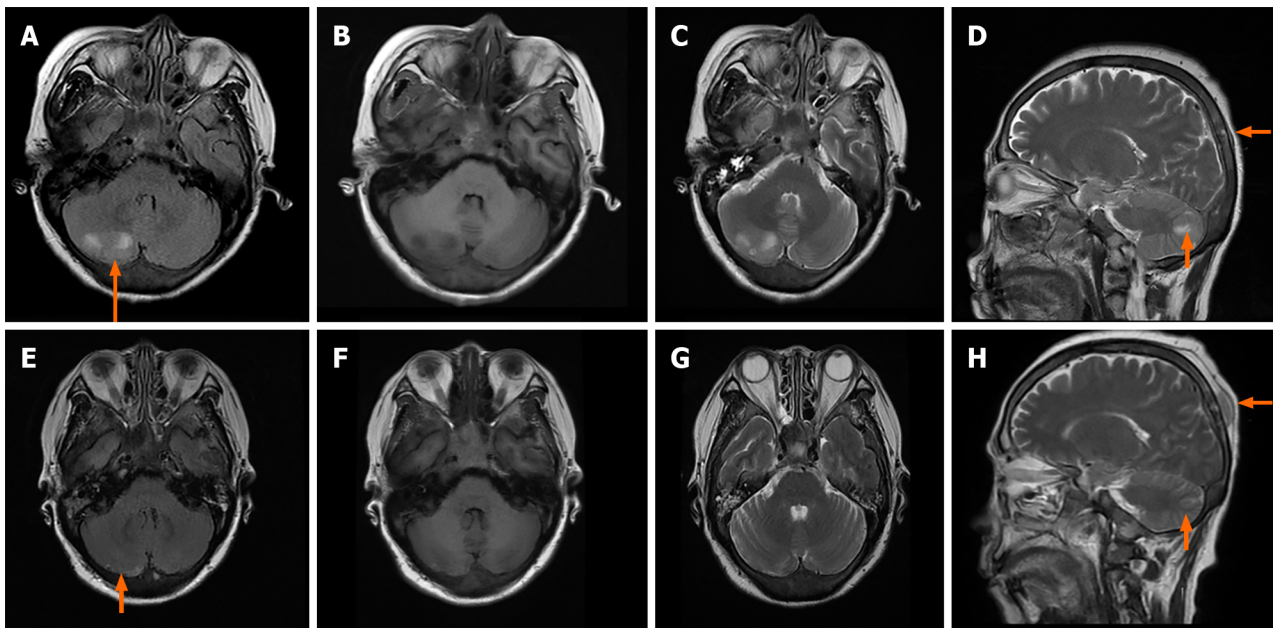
Enhanced magnetic resonance imaging image of a patient with brain metastasis undergoing savolitinib treatment. A: Fluid attenuated inversion recovery image (November 11, 2023); B: T1 image (November 11, 2023); C: T2 image (November 11, 2023); D: Sagittal view of T2 image (November 11, 2023); E: Fluid attenuated inversion recovery image (December 26, 2023); F: T1 image (December 26, 2023); G: T2 image (December 26, 2023); H: Sagittal view of T2 image (December 26, 2023). Orange arrow shows the tumor.
